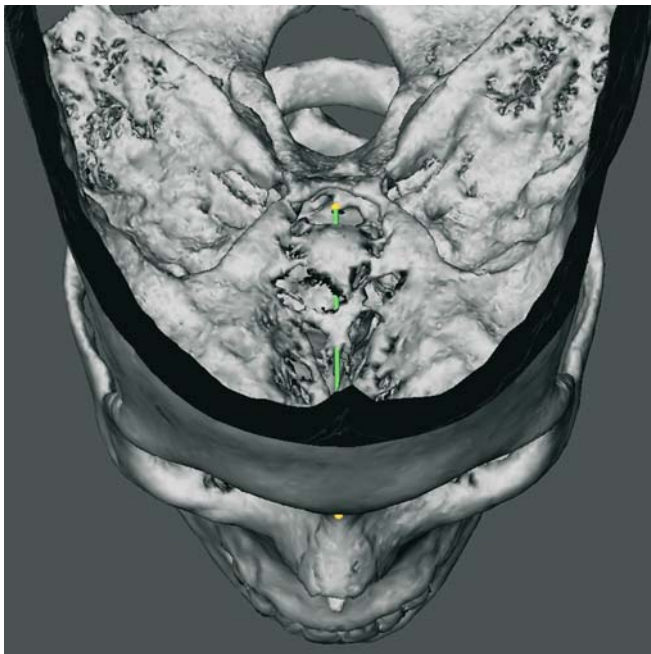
Anterior cranial base length, S-N (3-D CT, hard tissues, patient K.C.)
